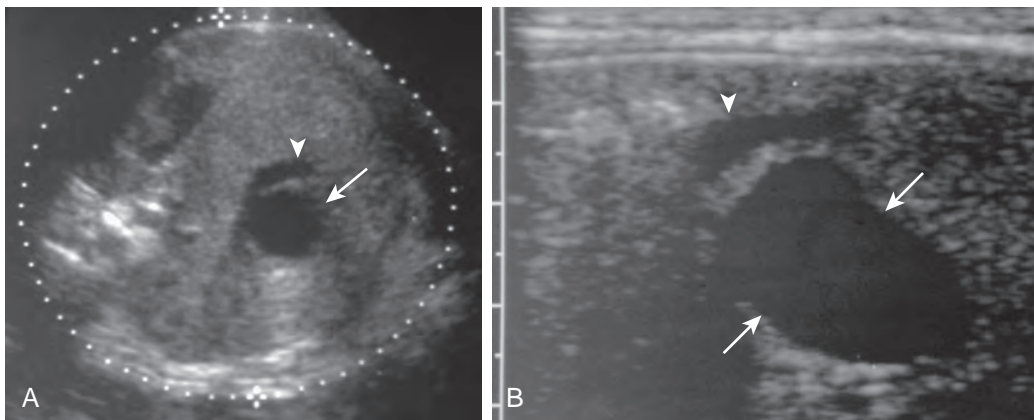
Prenatal diagnosis of choledochal malformation. A. Prenatal sonogram demonstrates a cystic structure in the periportal region (arrow). The gallbladder (arrowhead) is also identified. B. Postnatal sonogram of the same infant on the day of birth confirms the presence of a choledochal cyst (arrows) involving the extrahepatic bile duct. The gallbladder (arrowhead) is identified as a separate structure.
